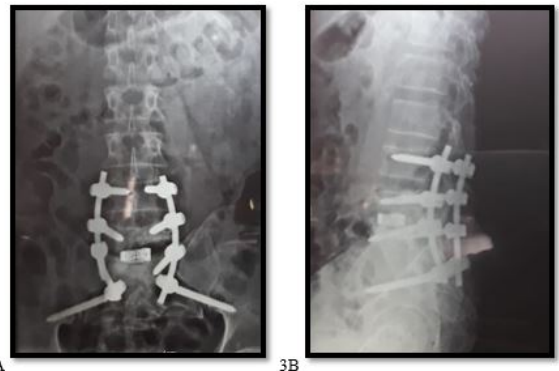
x-ray lumbosacral spine: suggestive of fixation at L4-5, S1-2 with transforaminal lumbar interbody fusion.
